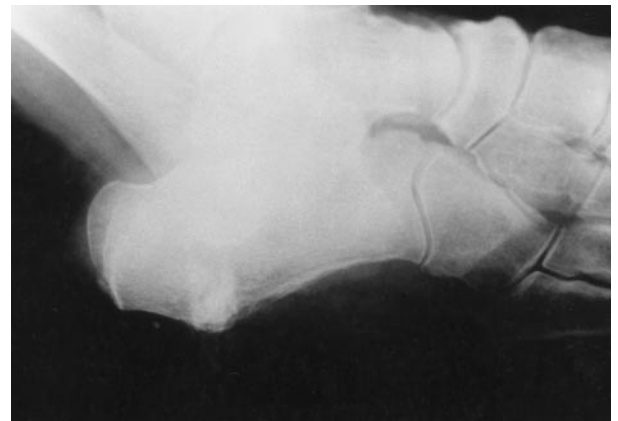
Oblique radiograph demonstrating extrusion with bone formation after hydroxyapatite packing of calcaneal bone graft trephine site.
